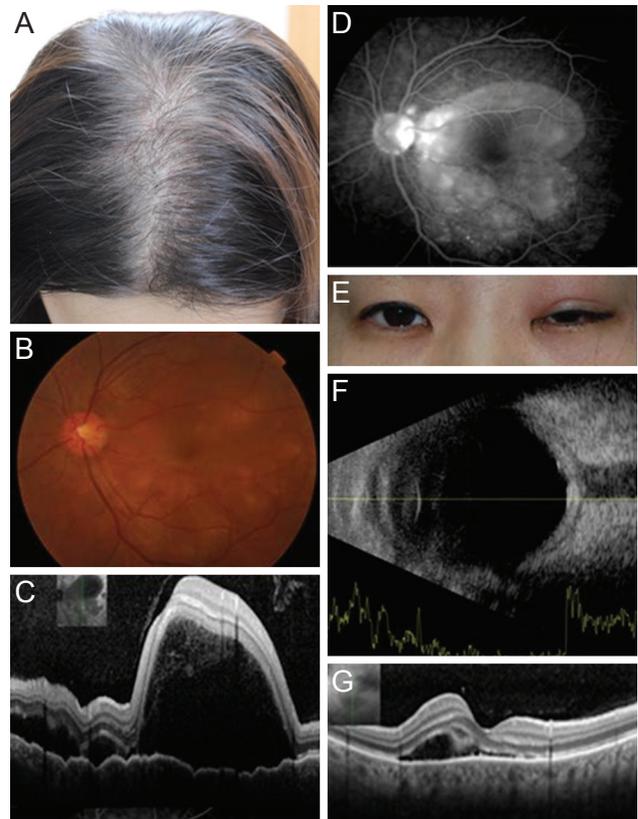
(A) Alopecia developed several months before ophthalmic symptoms. (B) Initial fundus photography of the left eye, diffuse serous retinal detachment was observed. (C) Initial optical coherence tomographs showed subretinal fluid with serous retinal detachment, involving macula. (D) Initial fluorescein angiography showed some leak points and pooling into the subretinal space. (E) Recurred state, there was upper lid erythema, swelling and ptosis. (F) Recurred state, the ultrasonographs showed the increased thickness of the posterior scleral wall and the typical T sign caused by the spread of inflammation along the Tenon's space into the optic nerve sheath. (G) Recurred state, the serous retinal detachment was relapsed in optical coherence tomographs. But it was less severe than initial state.
